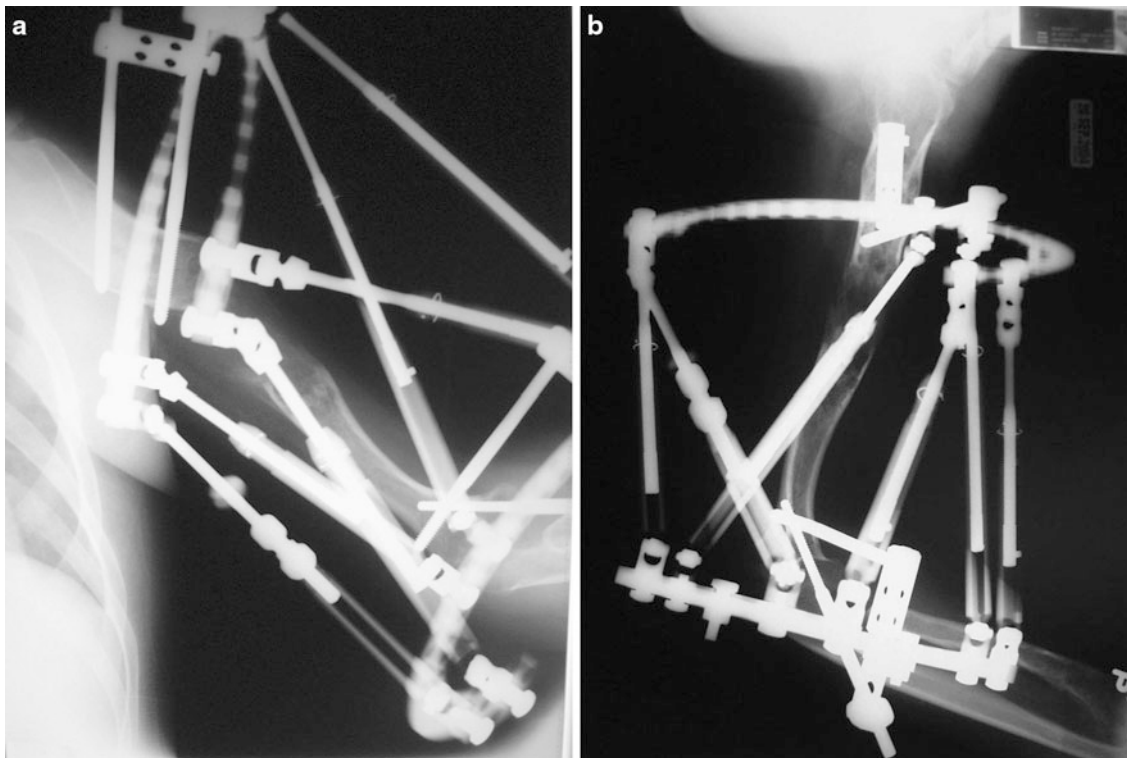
AP (a) and lateral (b) radiographs after goal length and deformity correction are achieved
